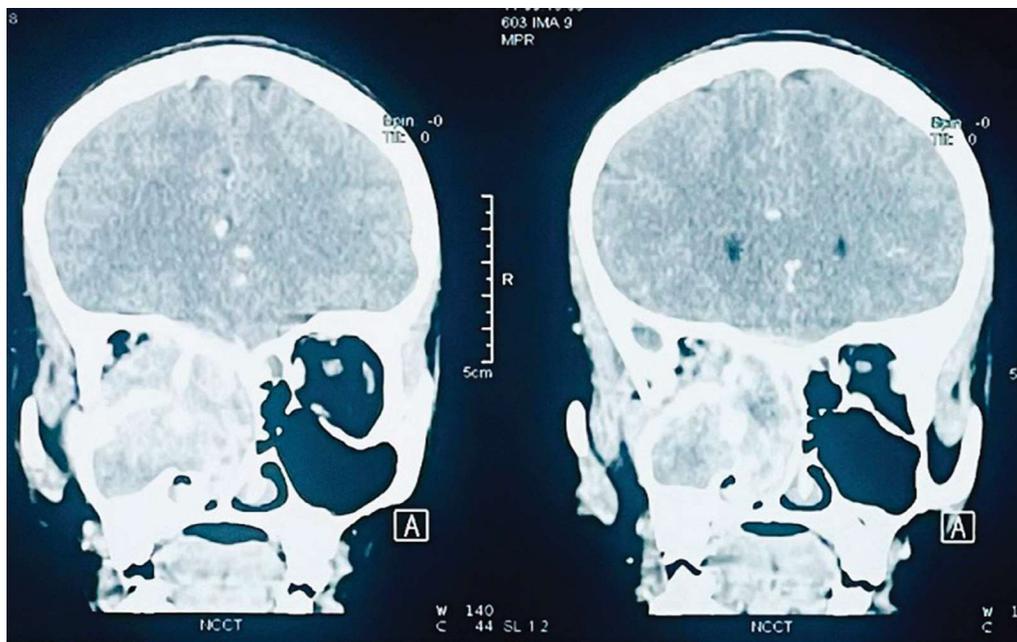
MRI Brain + Orbit: Solid soft tissue lesion in right sinonasal region with partial destruction of medial wall of right orbit
